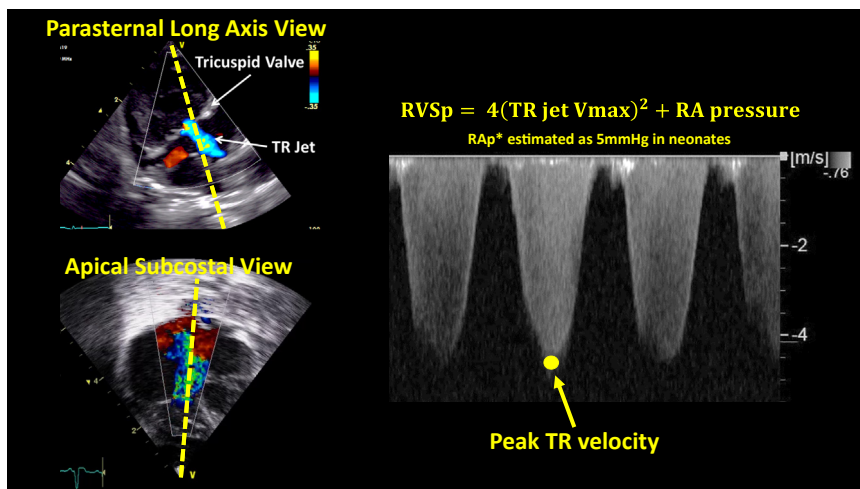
PAP measurement on the basis of pulsed-wave Doppler from the parasternal long-axis view. *mPAP*, Mean pulmonary artery pressure; *PADP*, PA diastolic pressure; *PADV*, PA diastolic velocity; *RAp*, right atrial pressure; *RVSp*, RV systolic pressure.
